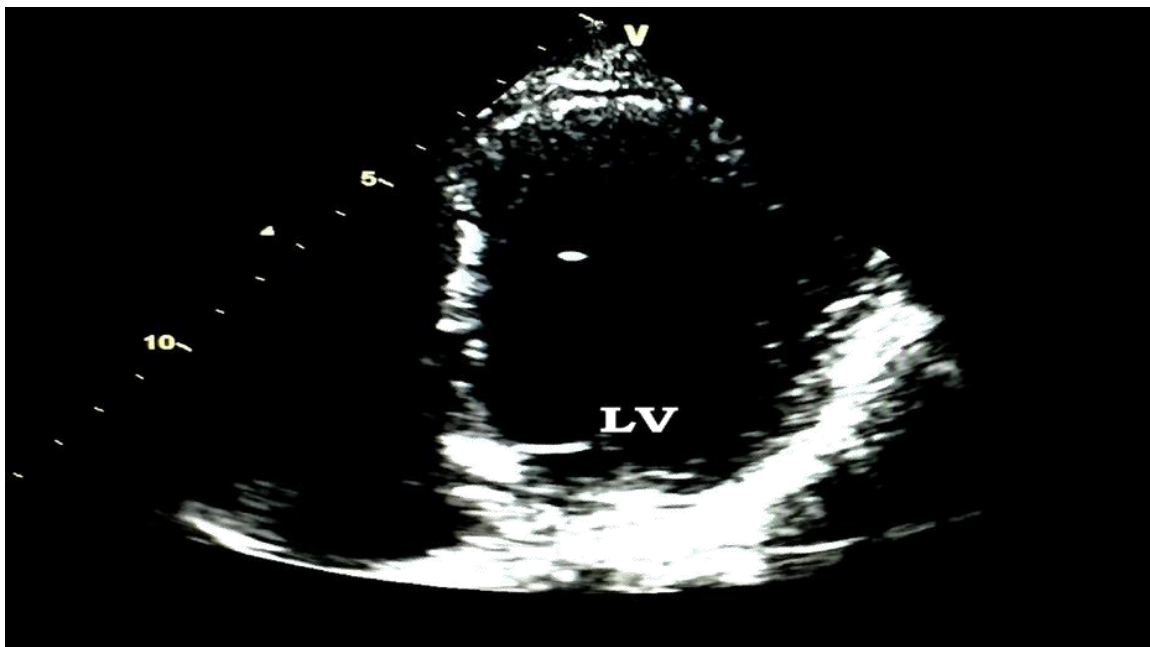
Echocardiographic 4 chamber view of the left ventricle during the follow up visit, 2 weeks later after being treated with low molecular weight heparin and dual antiplatelets. Note the complete resolution of the LV thrombus.
